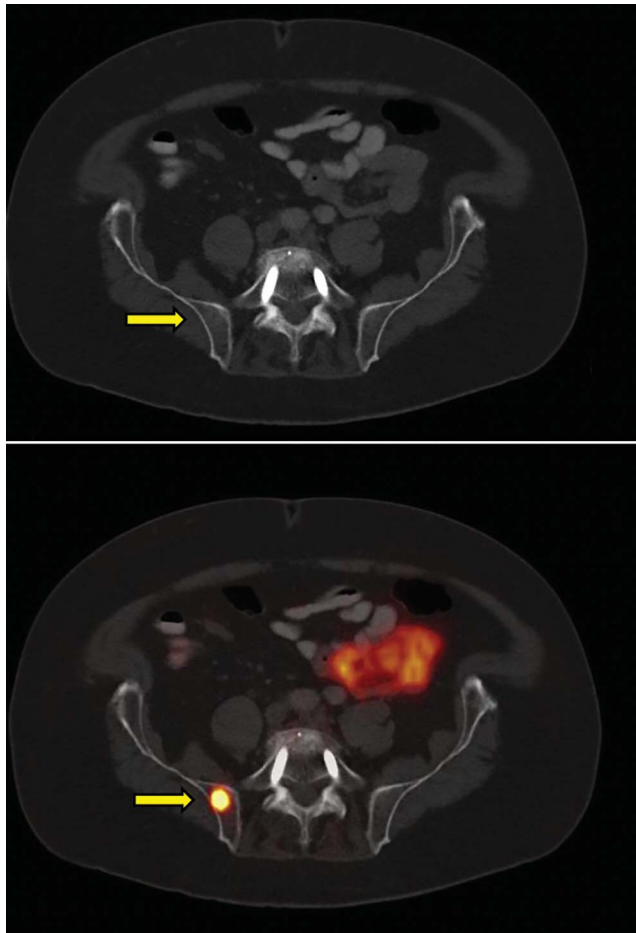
Increased sensitivity of PSMA PET/CT for bony lesion (arrows). CT scan (top) shows no abnormalities, but a lesion of PCa with high PSMA expression (bottom) is apparent in the right ileum. Even in retrospect, the CT scan was unrevealing. Because of the increased sensitivity and specificity, PSMA PET/CT has been added to the NCCN Guidelines for 2021.¹
